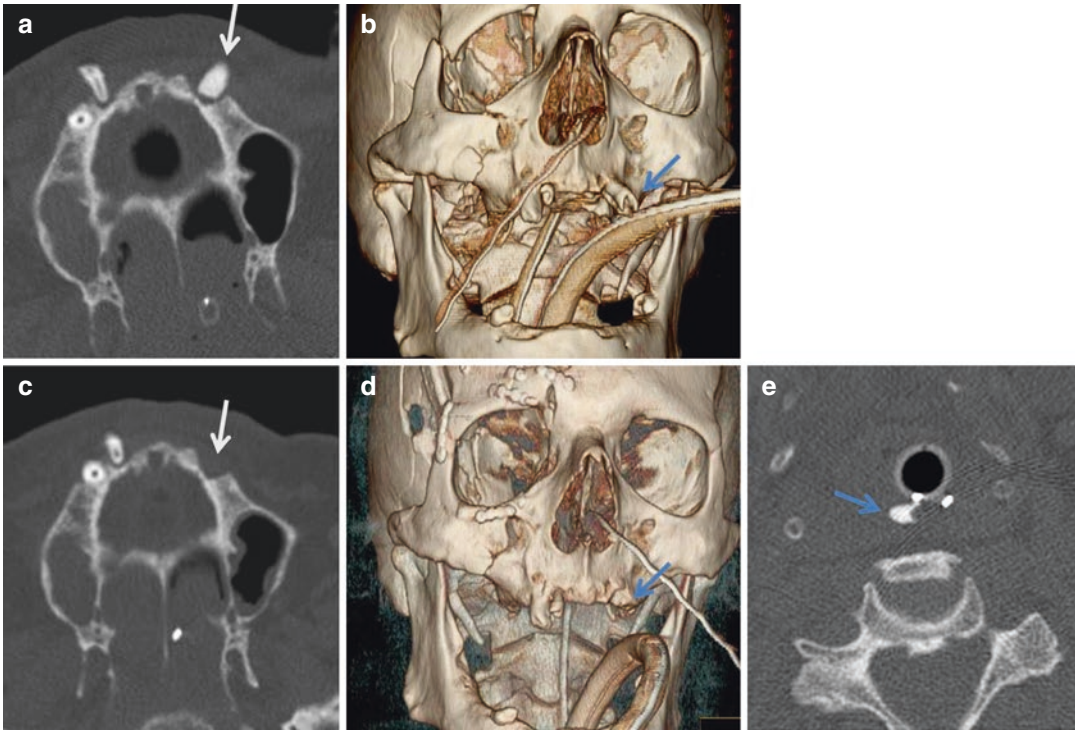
CT scans of a patient before (a, b) and after (c, d) multiple facial fractures fixation, showing a missing teeth (arrow). In these cases a careful search for a swallowed or as in (e) aspirated teeth is mandatory
